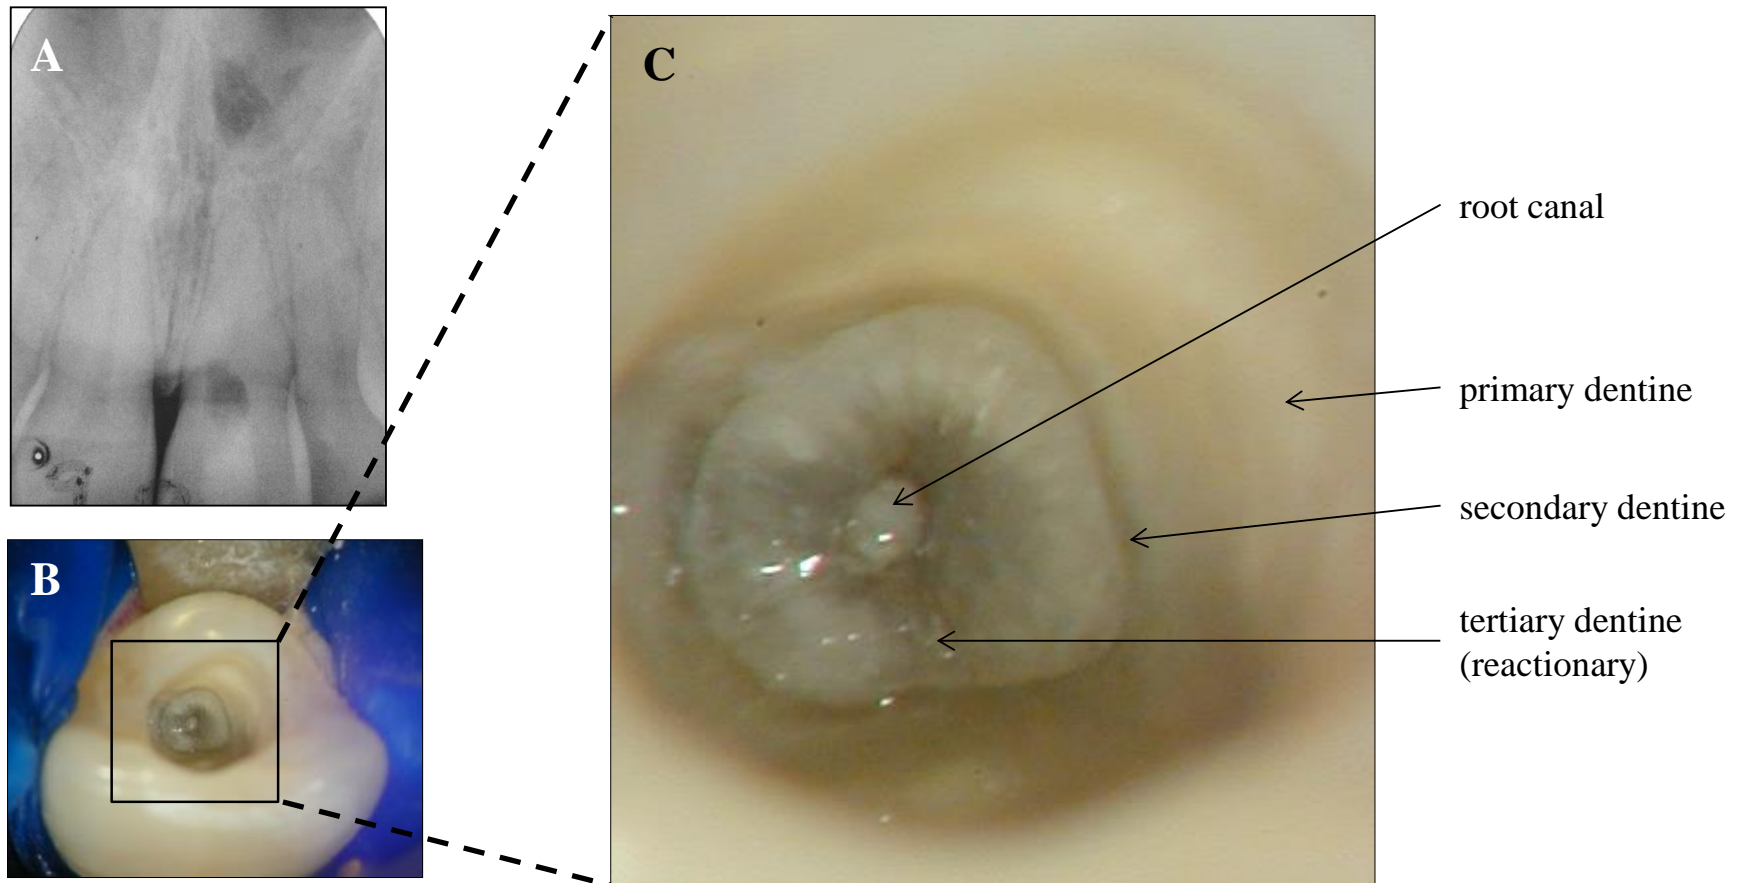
A case of a 24 year old female patient who had suffered trauma to her maxillary incisor 7 years earlier. A) Pre-operative periapical radiograph of maxillary central incisors following GDP's attempt to find the root canal. B) Access cavity in left maxillary incisor and C) higher resolution image of (B). This shows primary dentine to be a "creamy" colour. Secondary dentine is a darker colour compared with the primary dentine. Tertiary dentine is clearly demarcated by peripheral secondary dentine and has an "icy" mottled appearance interspersed with a more grey coloured dentine. The canal can be seen located in the centre of the tertiary dentine suggesting that the tertiary dentine was deposited at an equal rate by the odontoblasts lining the pulp chamber (clinical case by author).
